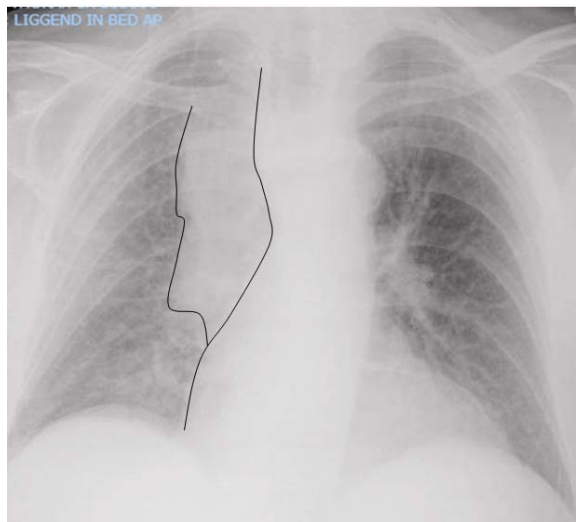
Thoracic X-ray: enlargement mediastinum.
